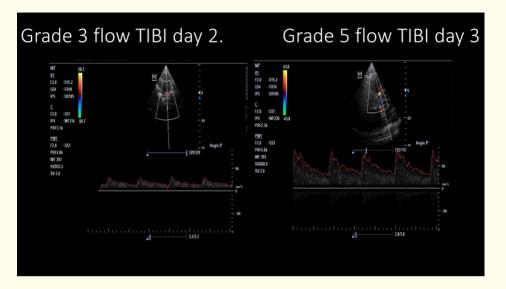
Spectral doppler of the same patient revealing improved blood flow in thrombolysis in brain ischemia [TIBI] grade due to recanalization.
